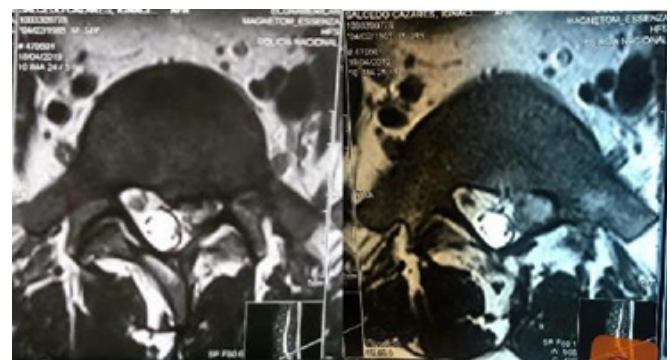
Axial MRI of L5, herniation is observed.
